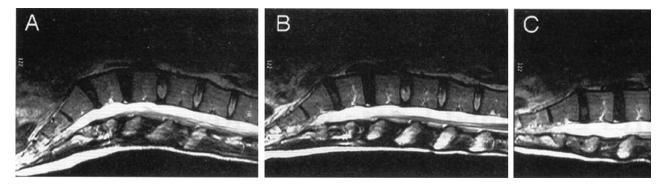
T2-weighted magnetic resonance images showing midsagittal slices of the lumbar spine from a 34-year-old woman. Images were obtained in the supine position with (A) knees straight, (B) slightly flexed, and (C) fully flexed. The maximum downward angle of the lumbar spinal canal in the cephalad direction against the plane of the magnetic resonance platform was 14° in (A), 7° in (B), and 0° in (C), the fully-flexed leg position. From Hirabayashi et al.⁶⁰
